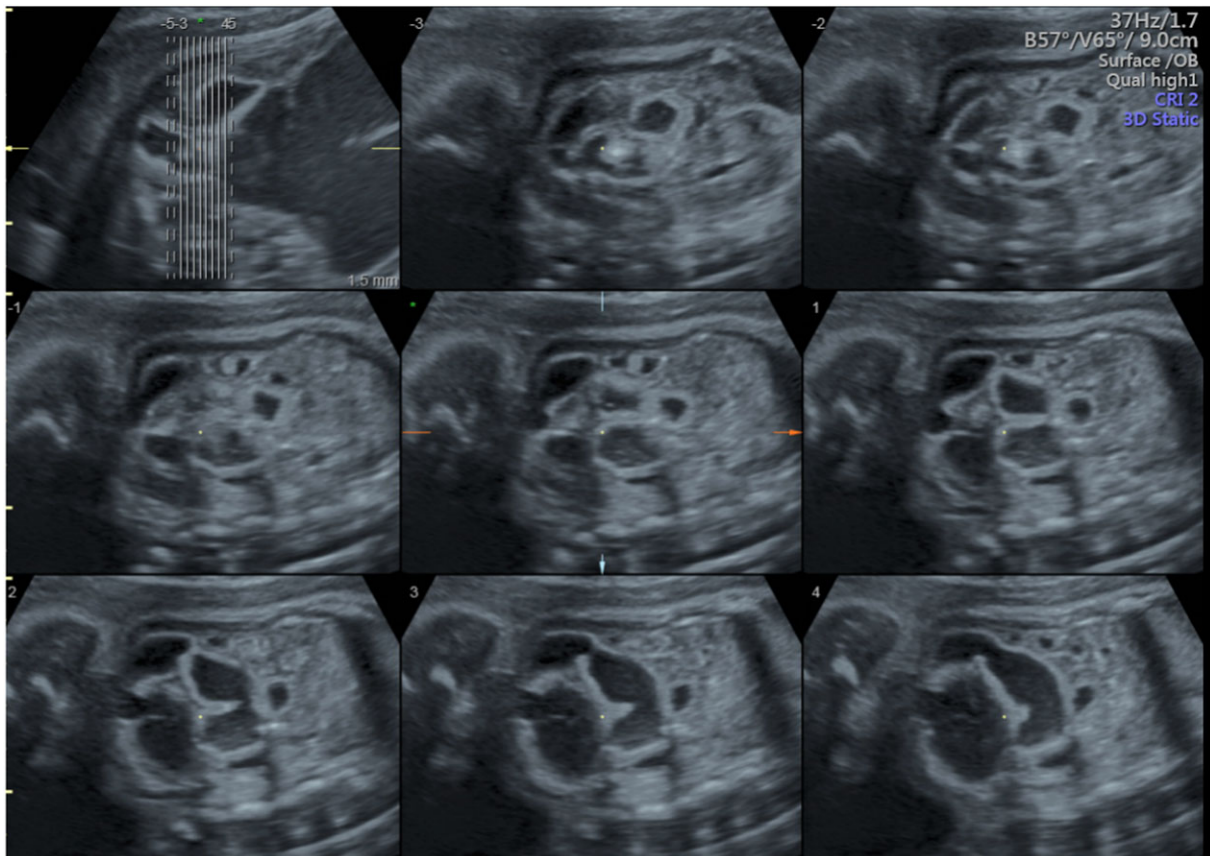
Case #4, 27 weeks of gestation. Prenatal midgut volvulus: Ultrasound features: whirlpool sign in 3D mode and multiple plane examination [Colour figure can be viewed at wileyonlinelibrary.com]
